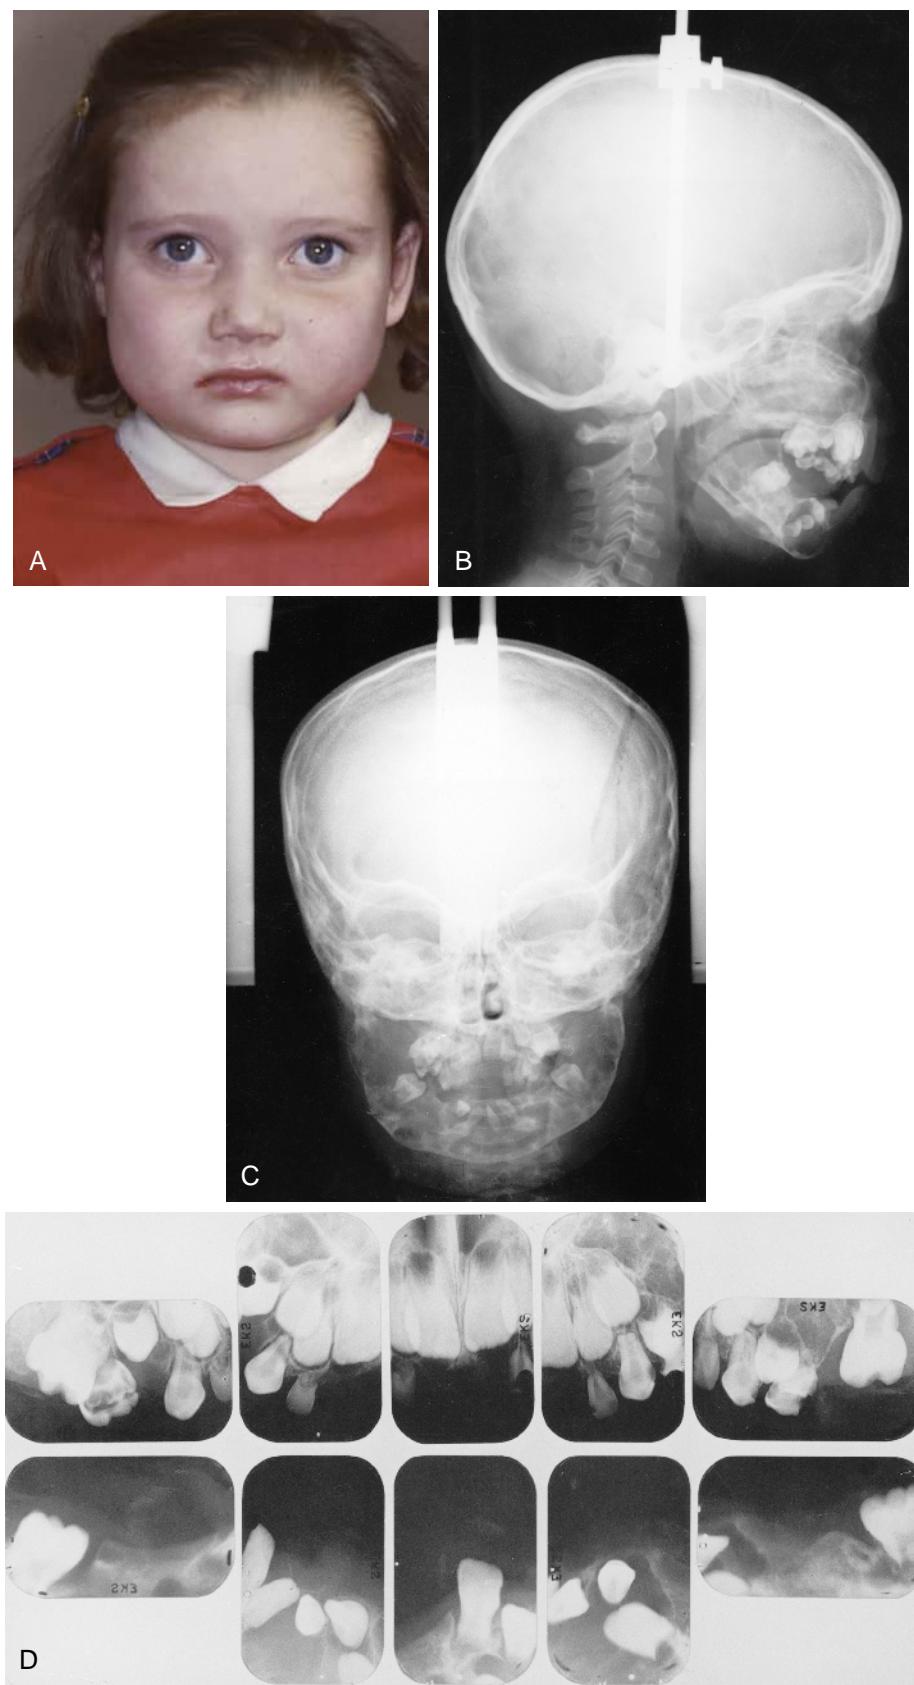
(A) Enlargement of the cheeks caused by bilateral bulging of the bone of the mandible. (B and C) Lateral and anteroposterior cephalometric radiographs. Notice the displacement of the mandibular anterior teeth in a large area of bone destruction, the locular cystic involvement of the mandible and maxillae, and the number of missing teeth. (D) Full-mouth radiographs demonstrating large areas of bone destruction and several missing teeth.
